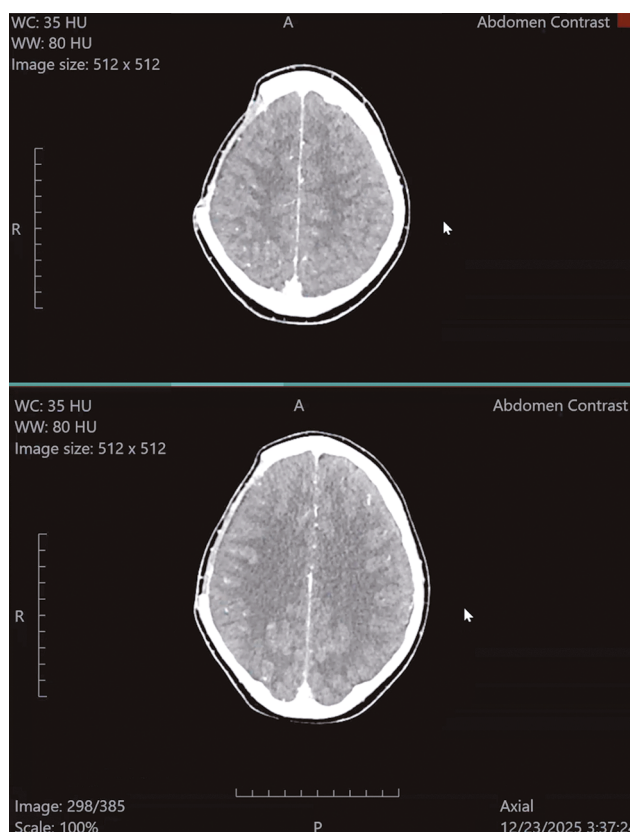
Follow-up contrast-enhanced CT, axial plane. Postoperative changes after resection of the right parietal bone metastasis, without visible residual cranial mass on the presented images
